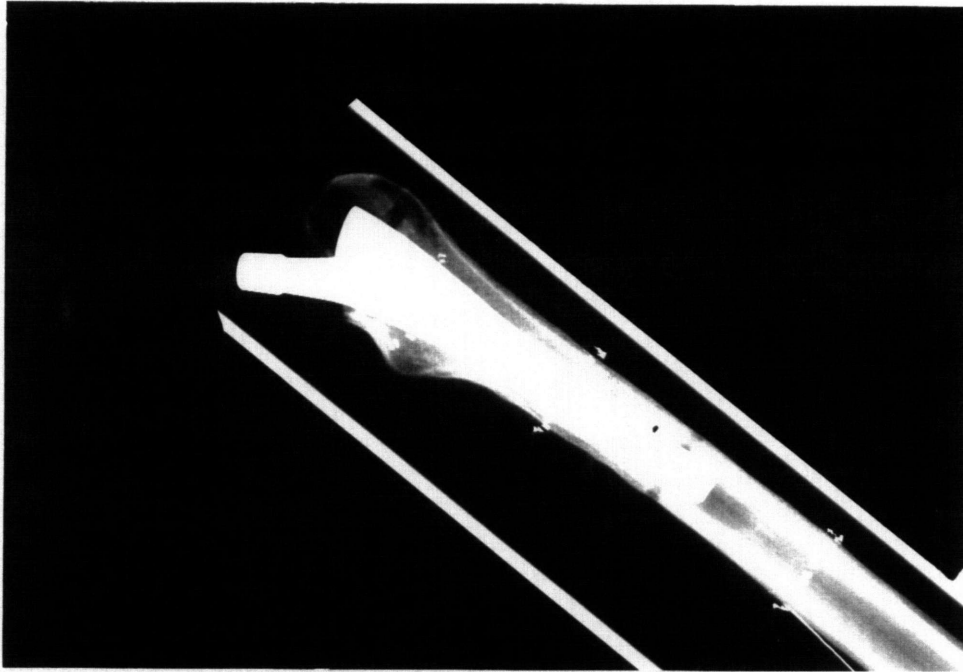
(continued) - (c) Radiograph showing the position of the prosthesis in bone 2 from the medial-anterior side; (d) Radiograph showing position of the prosthesis in bone 3. Note the difference in distal stem position from bone 2 (Fig. 3.2b).
